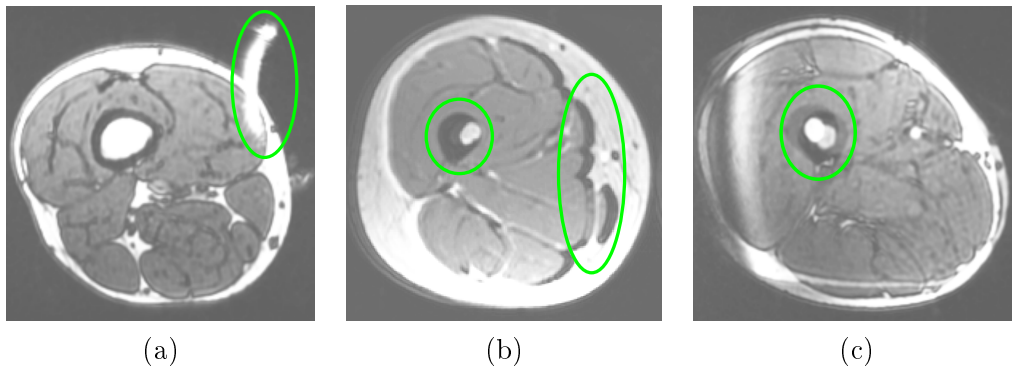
Some common MRI artifacts: (a) surface coil artifact on one distinctive spot, (b) tissue shift artifact on two distinctive spots (bone and fat tissue shifts), and (c) subject motion artifact at the overlap between two consecutive slabs where the femur is clearly shifted.
